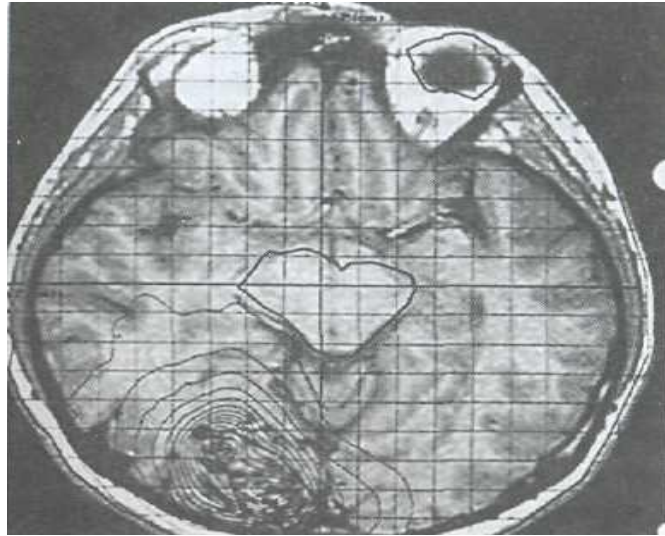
Stereotactic radiation may be used to obliterate small, unruptured arteriovenous malformations (AVMs) in eloquent brain. T₁-weighted MRI scan shows isodose radiation curves for treatment of an AVM.
